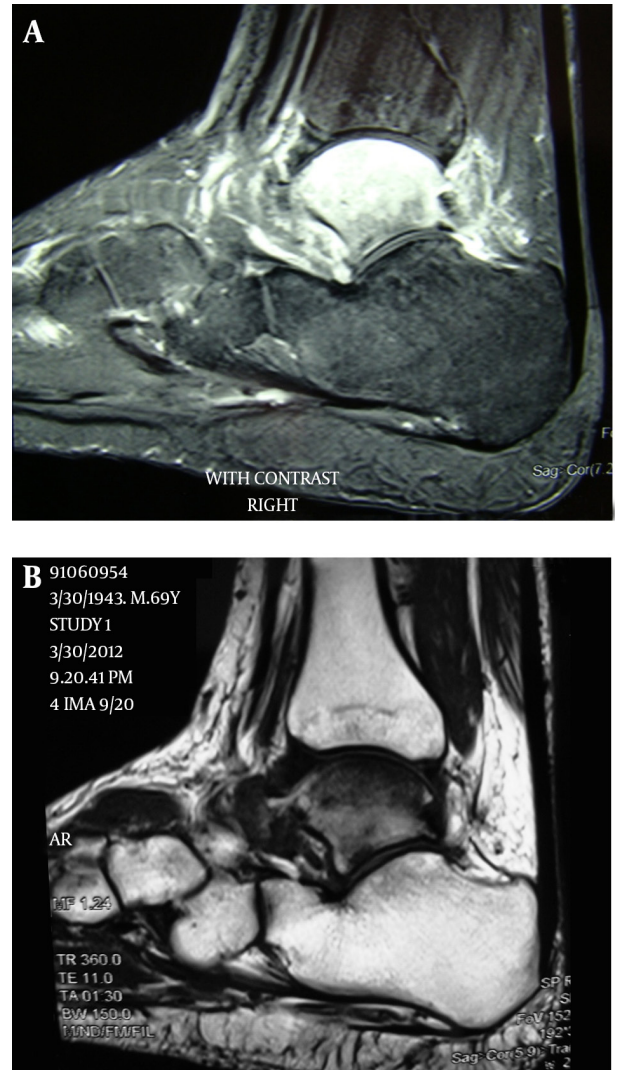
A, Lateral T2-weighted MRI showing increased signal intensity; B, lateral T2-weighted MRI showing decreased signal intensity in the talus. Bone marrow edema syndrome consistent with these findings.
